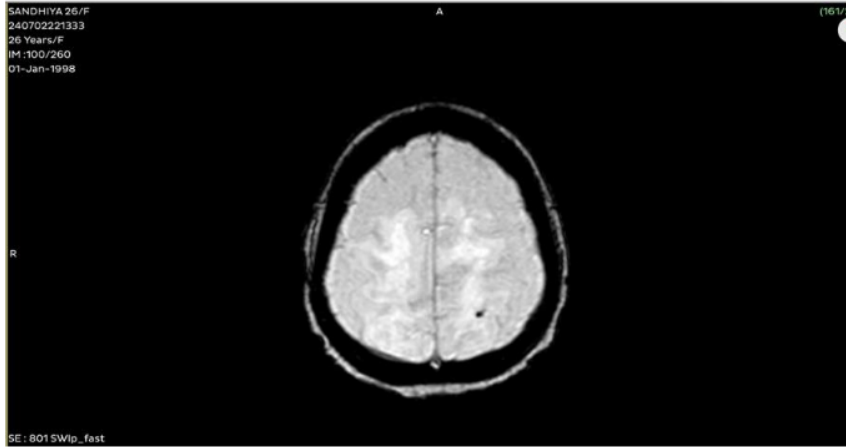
MRI BRAIN – SWI
